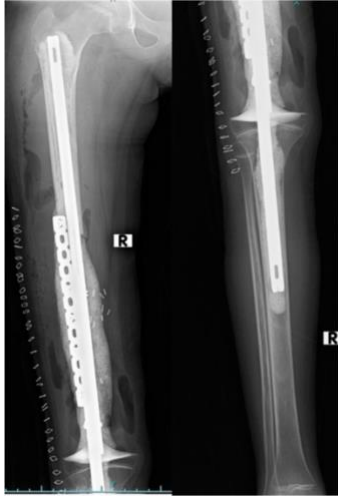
Post-op X-ray of patient 1 showing nail cement spacer covering the distal femur bone gap; arthrodesing the knee joint, reinforced with plate and screws
